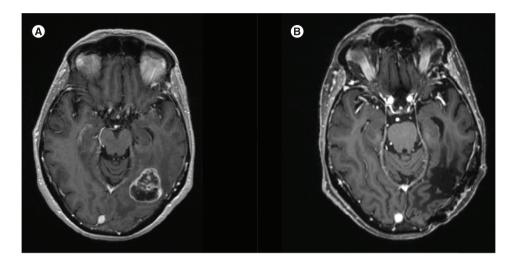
Brain MRI, postgadolinium enhanced T1-weighted axial imaging. (A) Baseline MRI at time of diagnosis in 2009 showing a $3.8 \times 3.2 \times 3.2$ cm peripherally enhancing left temporoparietal mass. (B) Surveillance MRI in January 2022 showing surgical resection cavity and gliosis in the left posterior temporal-occipital region with no mass effect or abnormal enhancement.
